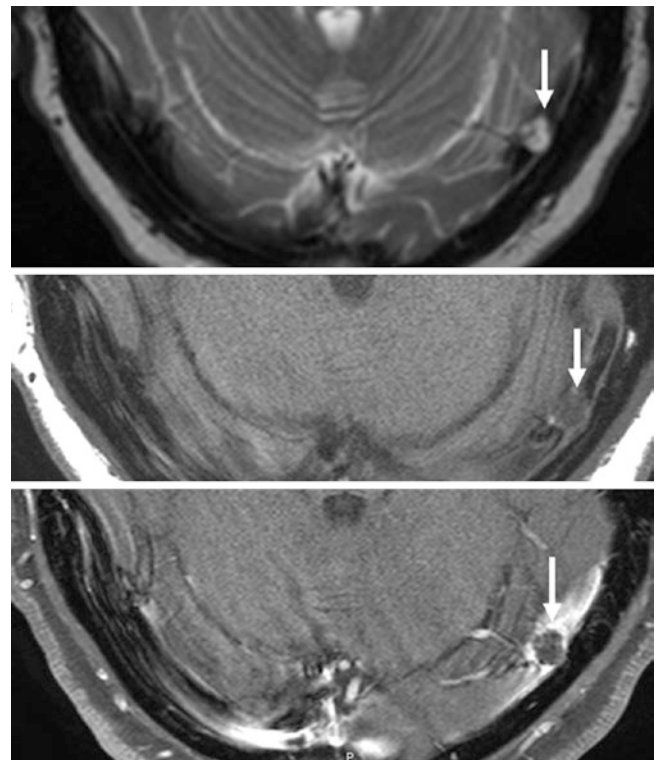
66-year-old with headaches. *Top*: an incidental left TS arachnoid granulation (*arrow*) is seen on T2WI MRI. *Middle and Bottom*: the arachnoid granulation is shown on both precontrast (*middle*) and postcontrast (*bottom*) T1WI
